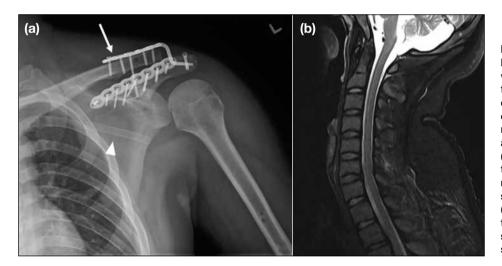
(a) Postoperative frontal left shoulder radiograph after 1 week showing interval internal fixation of the scapula and clavicle (arrow) and reduction of acromioclavicular joints. The metallic stent for subclavian artery dissection was also evident (arrowhead). (b) T2-weighted turbo spin echo sagittal magnetic resonance imaging of the cervical spine with fat suppression (repetition time: 3040 ms, echo time: 66 ms) showing normal spinal cord without abnormal cord signal.
